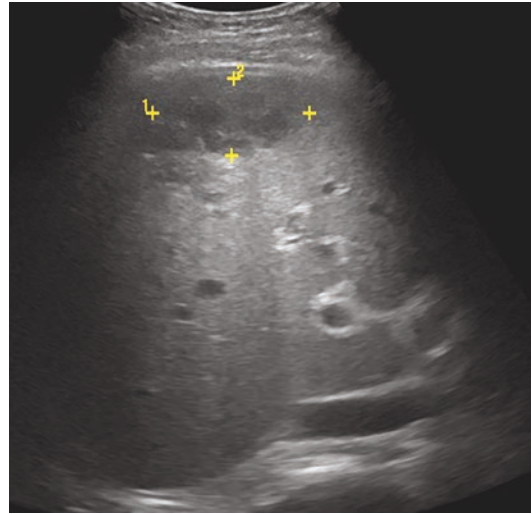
Abdominal sonography: a heterogeneous, hypoechoic mass in the segment 8 of liver, without internal calcification
